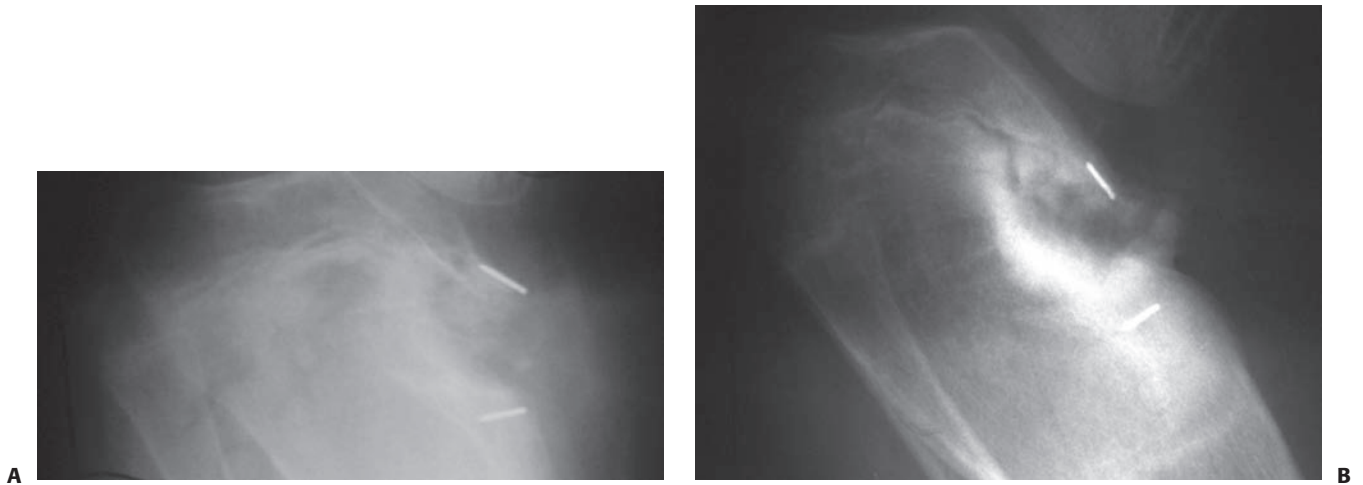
Resection of substantial physeal arrests in weight-bearing areas may allow subsidence of the articular surface. This is of particular concern in the proximal tibia of patients with infantile Blount disease. A: Early postoperative radiograph after partial physeal arrest resection in an obese patient with infantile Blount disease. B: One year later, the metallic markers are actually closer together, in addition to demonstrating increased varus. Subsidence of the medial proximal tibial articular surface is the likely explanation of this radiograph finding. Protected weight bearing or methyl methacrylate as the interposition material may be indicated in such cases.
